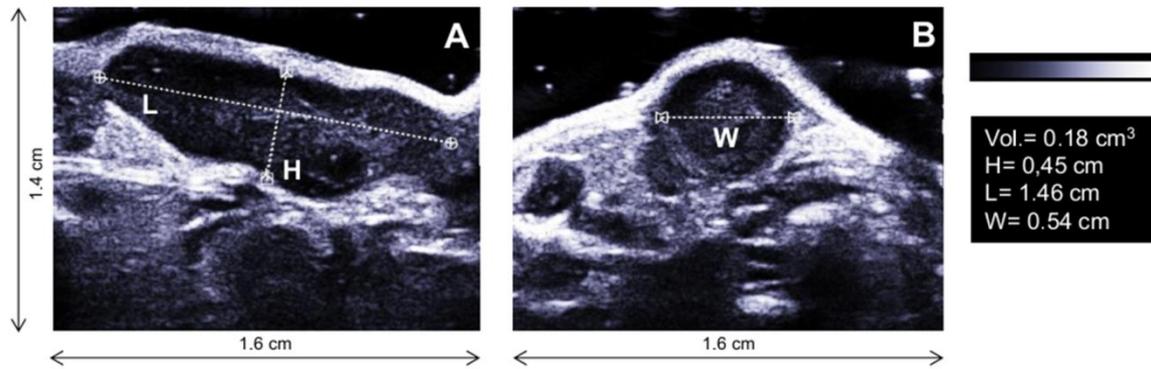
Tumour volume retrieval by conventional ultrasonic imaging. Tumour volume was calculated using the measured maximal diameters (length, height and width). The tumour length and height were measured in the axial plane of the tumour whereas the width was measured in the sagittal plane. The images correspond to one of the ectopic models on the 9th day.
